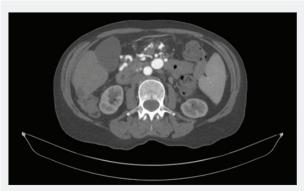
Preoperative CTA showing the 16-mm jejunal artery aneurysm.
